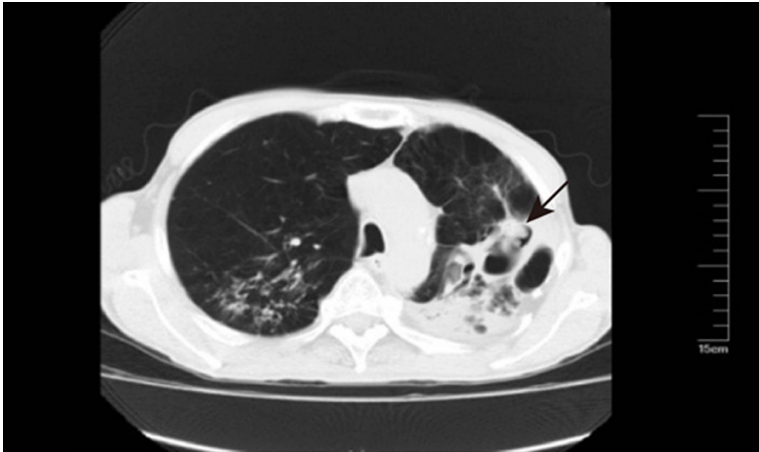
Computed tomography (CT) showing cavity in the left upper lobe with nodular bumps. Black arrow indicated cavity with nodular bumps.
